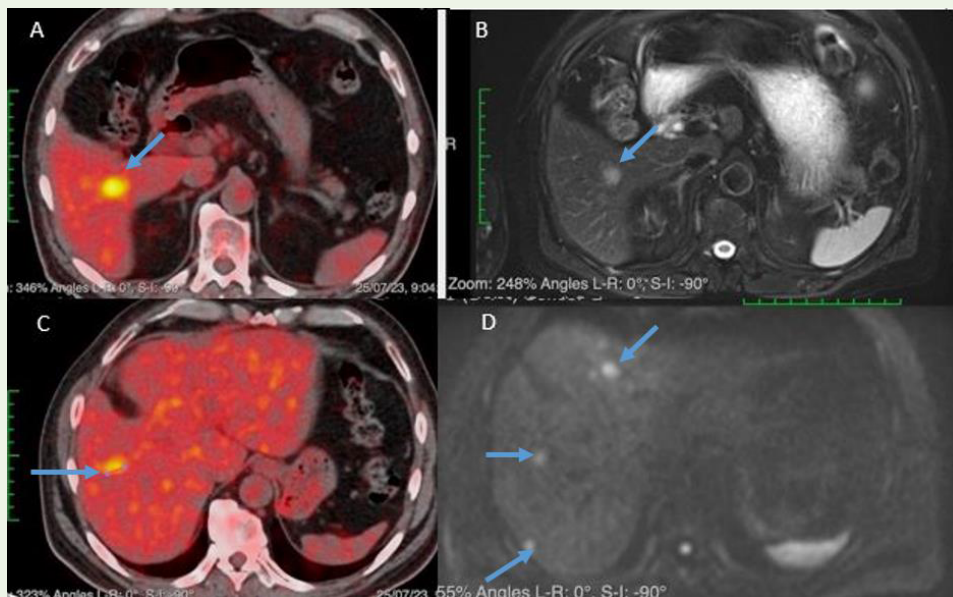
Image A and C: FDG PET-CT scan showing hypermetabolic liver lesions. Image B and D: MRI Liver (High B) scan showing multiple liver lesions with restricted diffusion.
